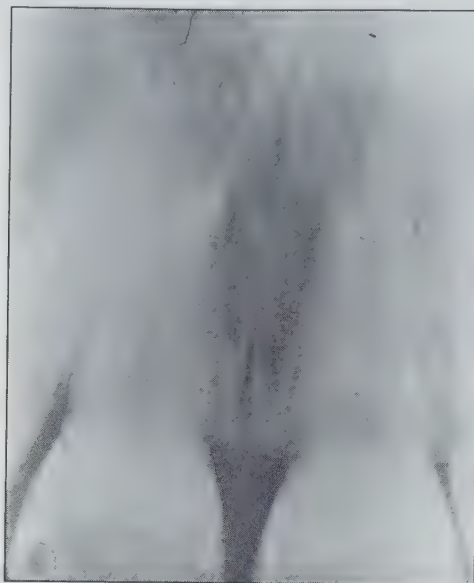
Periapical radiograph of an incisive canal cyst between the roots of vital central incisors. Pus was draining from a sinus tract at the incisive papilla. Due to acute inflammation, the borders of the radiolucent lesion are ill-defined. (Radiograph courtesy of Dr. R. Danny Coffin).
